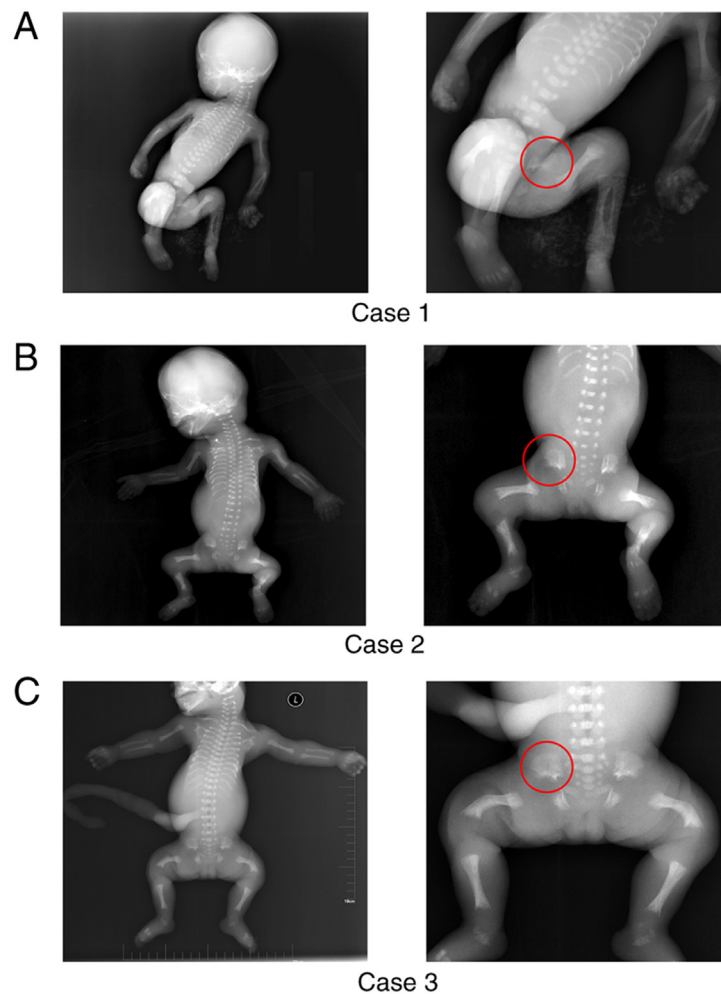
Radiographs of three cases of SRPS3. (A and B) Radiographs of retrospective SRPS3 samples. (C) Radiographs of the newly identified SRPS3 sample. In all three cases, we observed a trident appearance of the acetabulum (as indicated by the red ring); a long, narrow thorax with short ribs; shortened long bones; shortened femurs and remarkable spurs at the metaphysis of the long bones. Case 3 showed obvious congenital bowing of both femurs. SRPS3, short rib-polydactyly syndrome type III.
